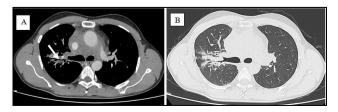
and 3B: Contrast enhanced soft tissue and HRCT lung window axial CT scan reveals adjacent peribronchial consolidation involving perihilar region of right lung, with air bronchogram and distorted dilated bronchi within. (marked by white arrow)
